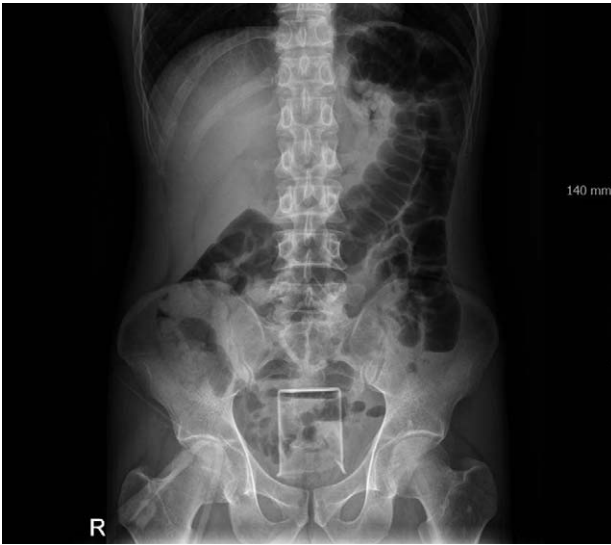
Pelvic X-ray, metal ring in pelvis.
